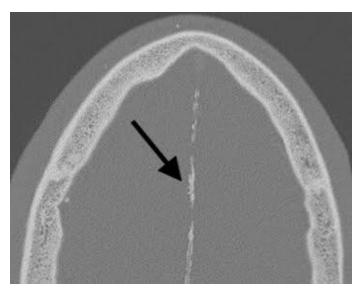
Prominent dural calcifications: Axial head CT demonstrating prominent calcification along the cerebral falx (arrow).
